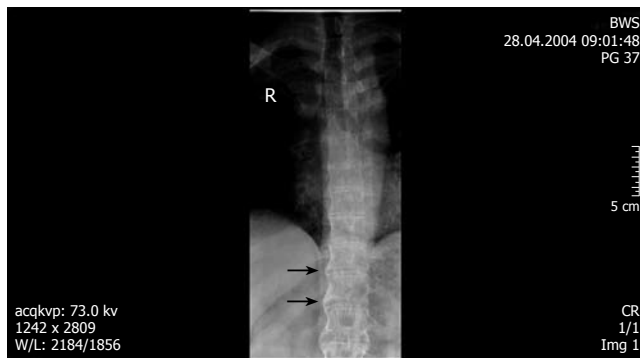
X-ray thoracic spine demonstrating ankylosing spondylitis (Bechterew's disease) with syndesmophytes/bamboo spine in a patient with CD.
